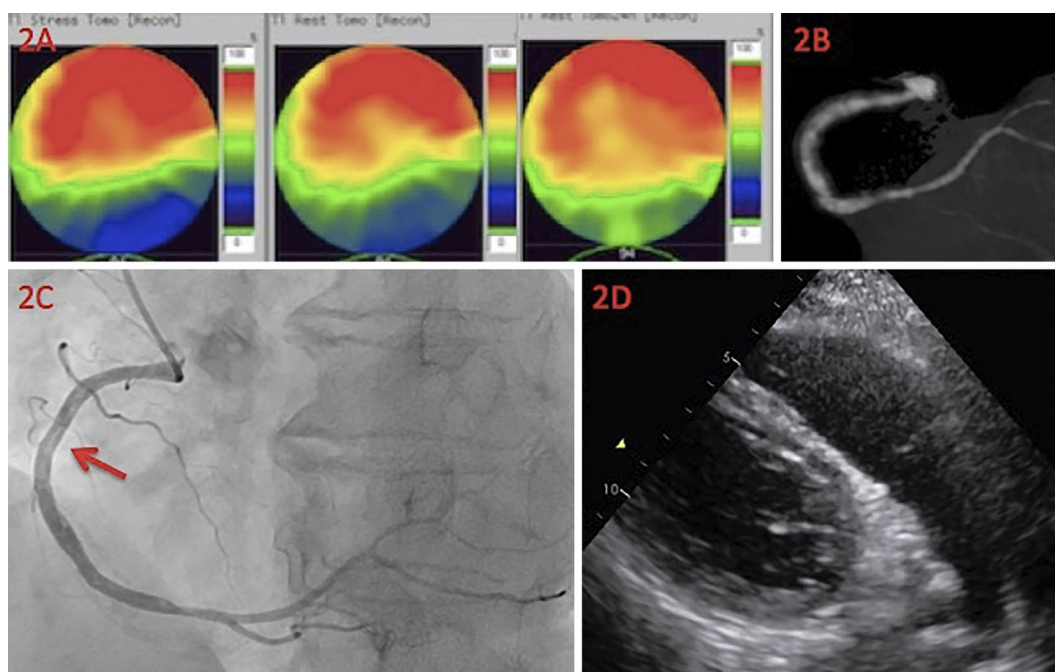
A: Stress myocardial perfusion ^{201}Tl scintigraphy (intravenous dipyridamole); left panel: an image immediately after the stress test shows the absence of any ^{201}Tl uptake in the inferior wall; middle panel: an image 4 h after the stress test shows the absence of redistribution of ^{201}Tl in the inferior wall; right panel: an image 24 h after the stress test shows the partial redistribution of ^{201}Tl in the inferior wall. B: Coronary computed tomography angiography shows recanalization of the right coronary artery. C: Coronary angiography shows recanalization with tiny thrombi (red arrow) in the proximal segment of the right coronary artery (left anterior oblique view). D: Transthoracic echocardiography shows disappearance of the thrombus in the RV at 2-month follow-up. RV: right ventricle, LV: left ventricle
